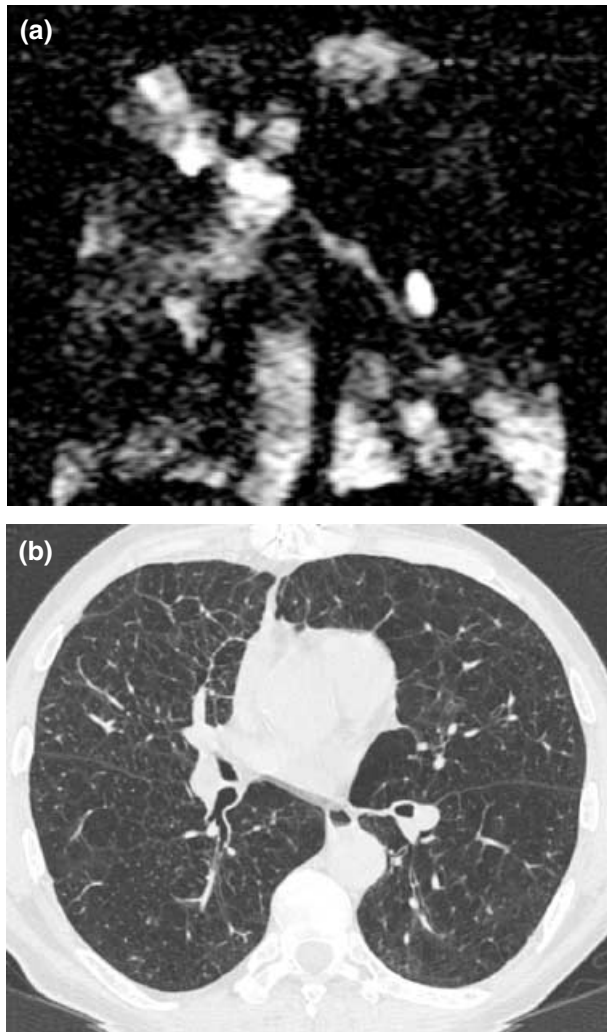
A 57-year-old male patient with severe emphysema. (a) Gas density image shows multiple widespread ventilation defects throughout both lungs; (b) corresponding CT shows emphysematous destruction in both lungs.
